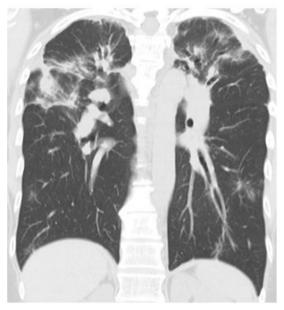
Fibrotic ground glass opacity is depicted on axial (A) and coronal (B) CT. Note that expansive hyperlucent area is associated along with bronchus and peripheral area. These lesions are distributed mainly to the upper lobes.
